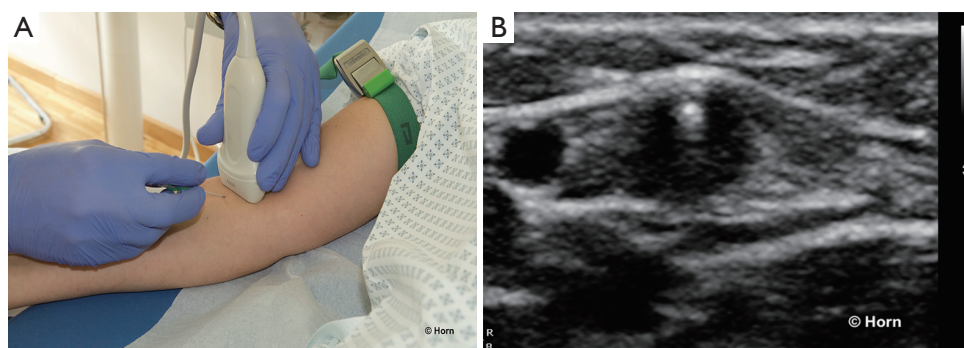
Transversal approach: the US transducer is placed transversally to the target vessel. (A) Needle insertion in the middle of the transducer; (B) RTUS-guidance of the course of the needle tip. US, ultrasound; RTUS, real time US.
